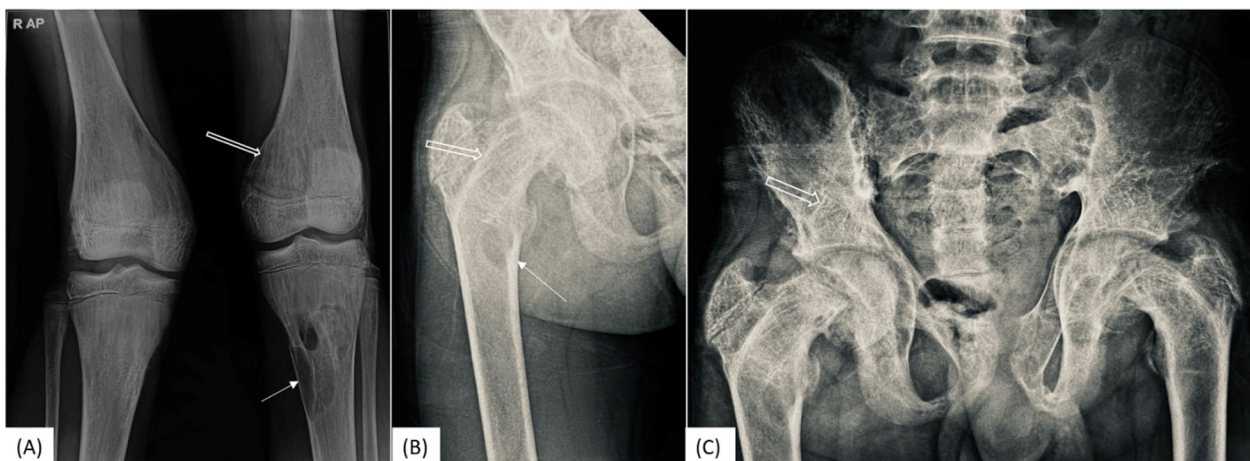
AP X-ray of the bilateral knee and the right proximal femur of the same patient A, B depicting multiple vertical striations (white outline arrow) in the meta-diaphyseal region suggestive of osteopathia striata with a multiseptated, lytic eccentric lesion (white arrow) in the proximal region of shaft of the femur and proximal shaft of left tibia with thin transition zone indicating brown tumors. C Pelvis shows various fan-shaped striations (white outline arrow) along the wings of bilateral iliac bones, as seen in osteopathia and bilateral protrusio acetabuli
